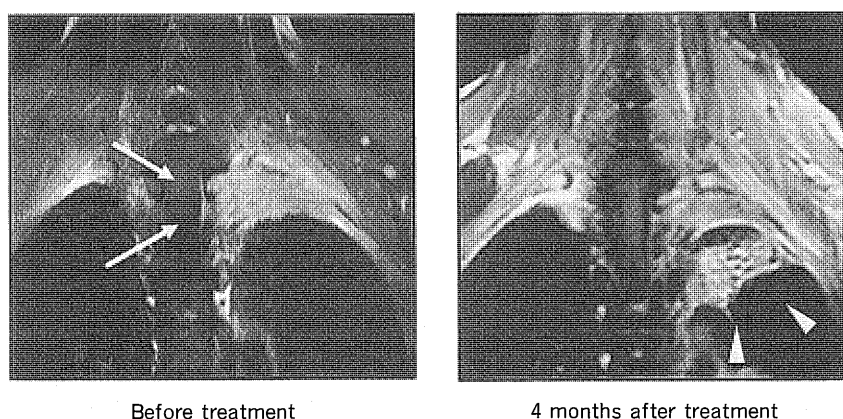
MRI of a Pancoast tumor detects an irregular enhanced tumor in the left apex of the lung. Prior to treatment, the tumor showed invasion on to the dura mater of the spinal cord (white arrows). The tumor shrank and lung fibrosis within the irradiated field was delineated 4 months after thermo-chemo-radiotherapy (arrowheads).
